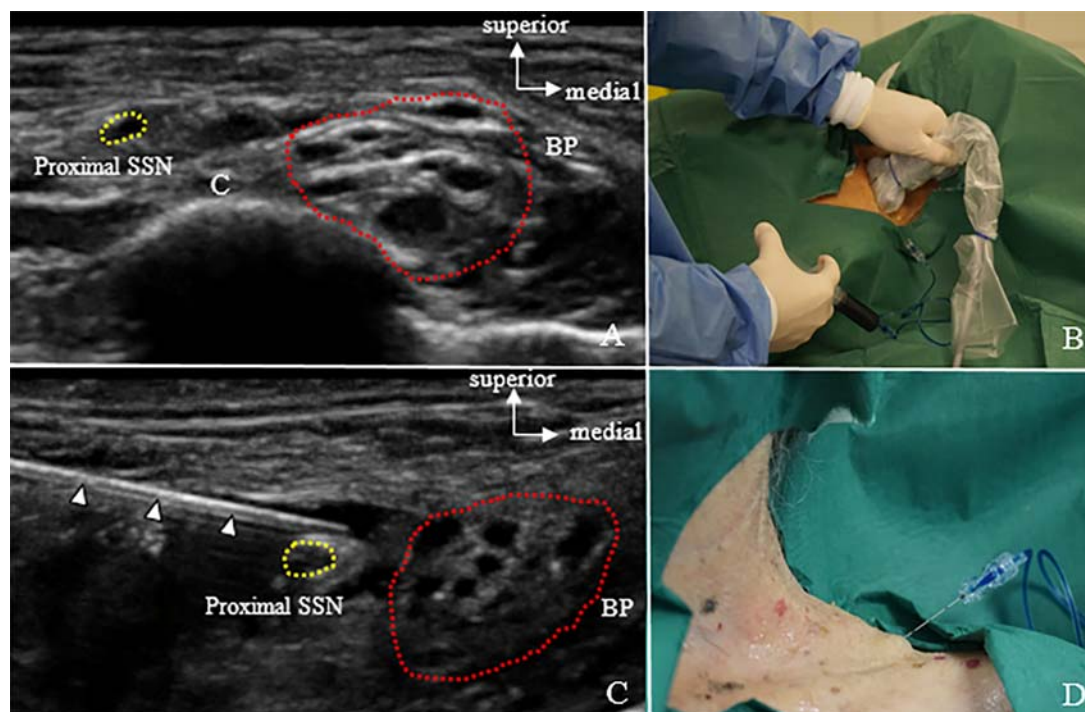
Proximal SSN Block. (A) The proximal part of the SSN was identified according to the “ski lift” ultrasound protocol. Please notice the short distance between the proximal SSN (yellow dotted line) and the Brachial Plexus (BP) (red dotted line). (B) A linear high frequency probe allowed us to realize the ultrasound guided proximal SSN block in the supraclavicular fossa. (C) Needle
